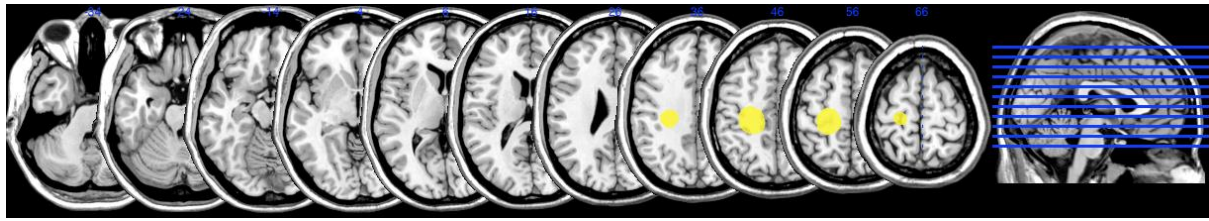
MRI scan of patient SO
